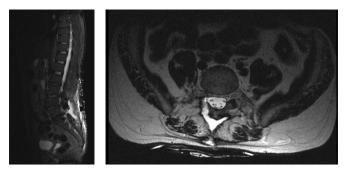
& Fig 12. MRI Spine: Sagittal and axial T2 weighted sequences [no legend as this has been embedded into text as the answer to a question] Answer
